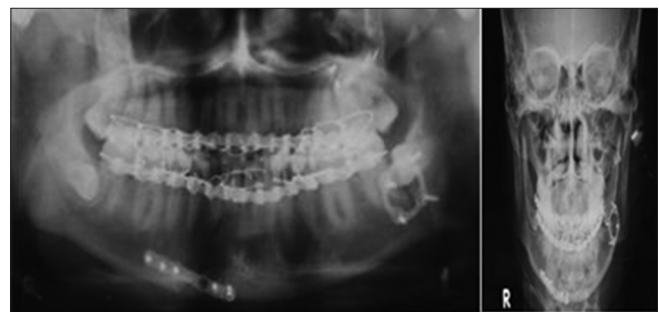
Post operative check X-rays
